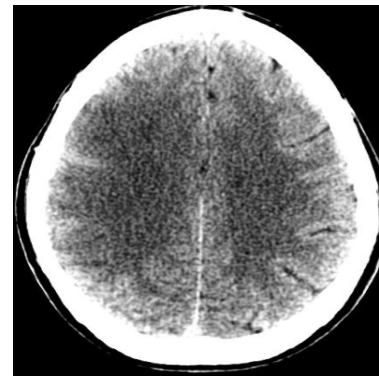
Figure Plain axial CT of Infarct noted in the right high fronto parietal region
